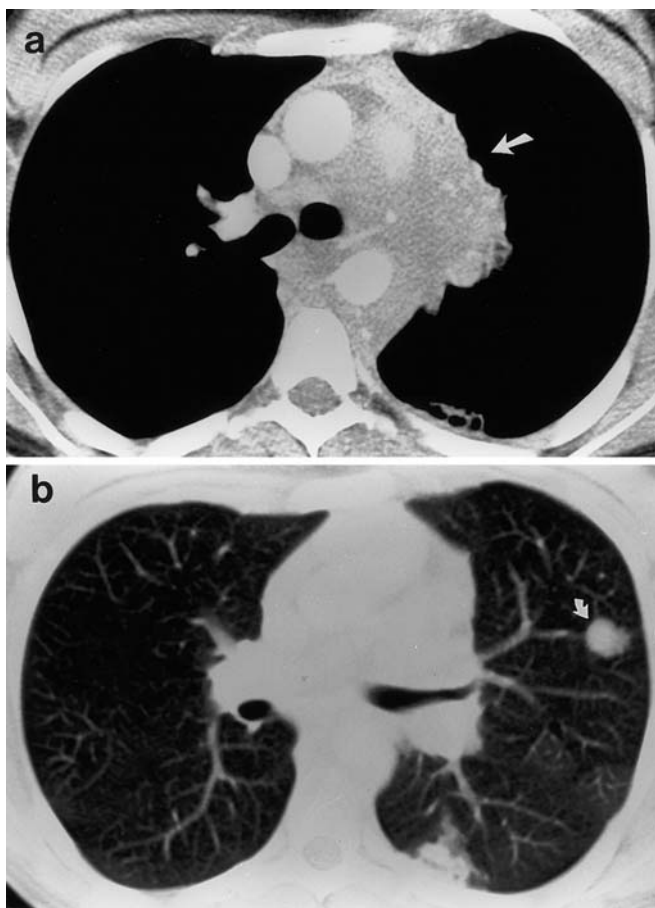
Invasive mediastinal aspergillosis. A 19 year old girl presented with a hoarse voice and difficulty swallowing. a The CT shows a large mediastinal mass infiltrating around the great vessels (*arrow*), and left hilum. b Lung windows demonstrate the presence of parenchymal nodules (*arrow*). Biopsy performed under CT showed invasive aspergillosis, and this was confirmed by mediastinal biopsy. There was no history of asthma, and despite extensive investigations no immunodeficiency was found. The patient responded to antifungal therapy, and remained well at 2 year follow-up
